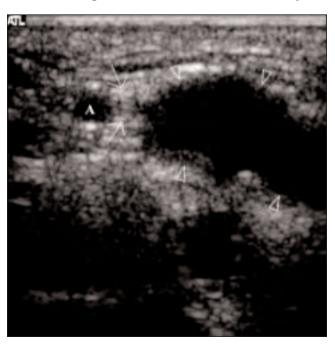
A ganglion cyst of Guyon's canal demonstrated by ultrasonography. This axial image shows the cyst (arrowheads) abutting the ulnar nerve (white arrows). A = radial artery.
